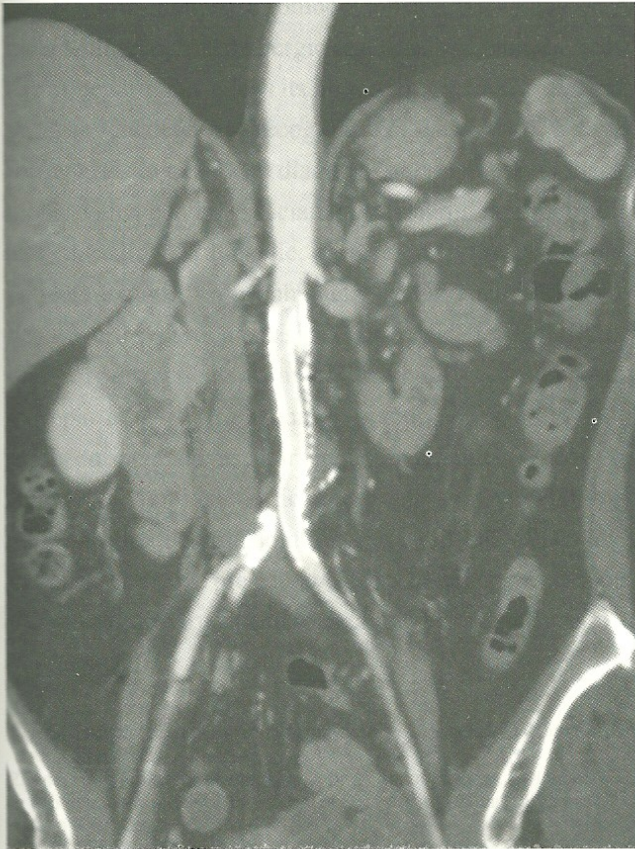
Postoperative CT scan: a good view of the inner tubing technique. The sacular aneurysm can be seen, and has been excluded
